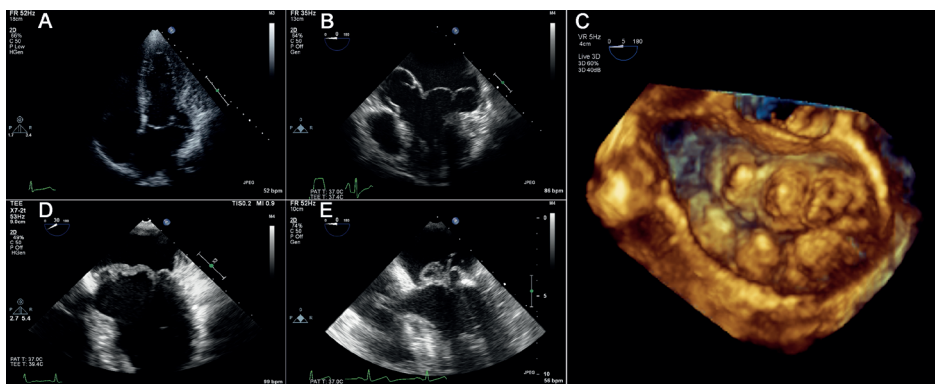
Type II-B billowing mitral valve leaflets due to chordal elongation seen with 2D transthoracic (A), 2D trans-esophageal (B), and 3D echocardiography (C: surgical view). Diffuse redundant and thickened leaflet tissue known as myxomatous Barlow's disease is seen with trans-esophageal echocardiography without (D: type II-B) and with chordal ruptures (E: type II-C).
